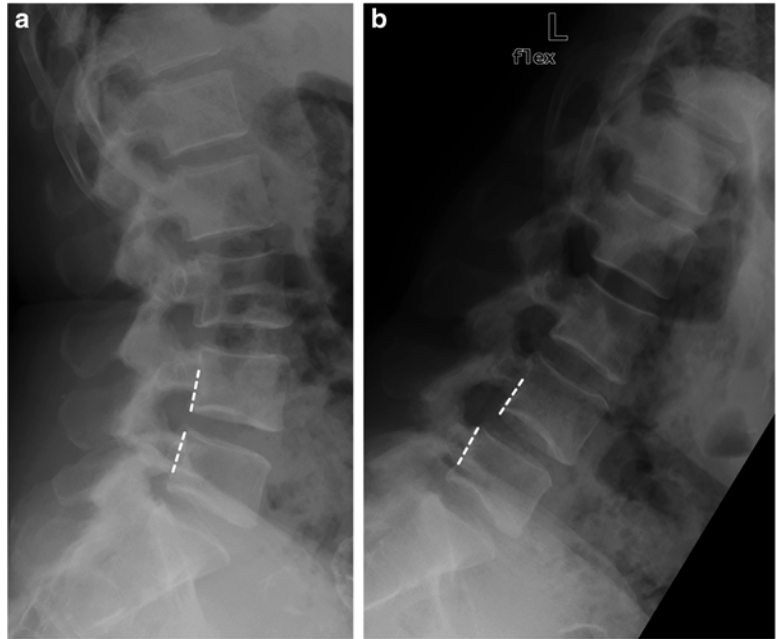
Angular instability in spondylolisthesis. (a) Lateral radiograph in the neutral position demonstrates anterolisthesis at L4–5. A defect is seen in the L4 pars interarticularis (*curved arrow*). The inferior endplate of L4 is approximately parallel to the superior endplate of L5 (*dashed lines*). (b) Lateral radiograph in flexion demonstrates a change in the angle between the involved
